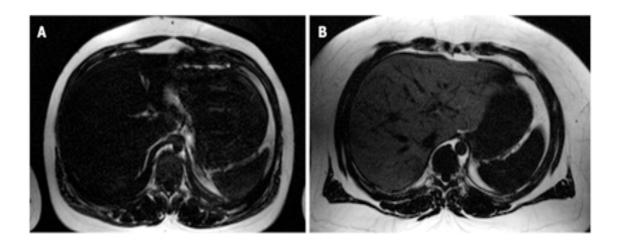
Fat-only axial MRI images of the abdomen. DIXON-MRI sequences allow the acquisition of fat-only images which allows visual comparison of a lean individual with low intrahepatic lipid and subcutaneous fat (A) with an obese individual with high intrahepatic lipid and subcutaneous fat (B) (Springer et al., 2010).
